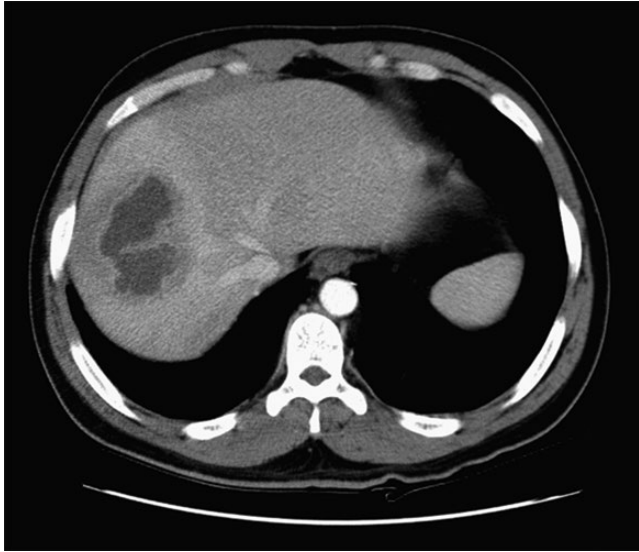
CT showing large fluid-filled liver abscess caused by *Staphylococcus aureus* in an adult presenting with fever and cough. (From Mueller 1998 [23]. Reproduced with permission of Thieme.)
